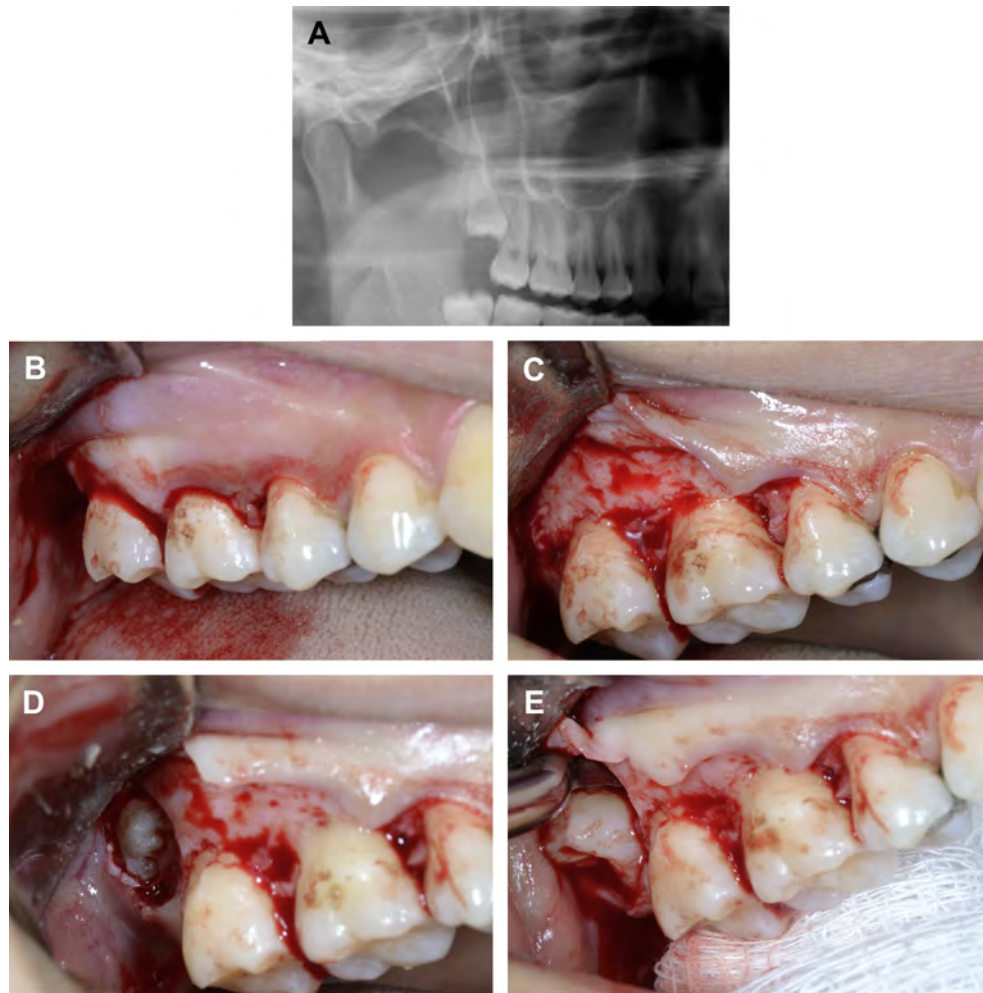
(A) Radiograph of impacted maxillary right third molar. (B) Envelope flap incision. (C) Reflection of envelope flap to access impacted maxillary third molar. (D) Bone removed overlying crown with fissure bur. (E) Impacted maxillary third molar delivered via rotation of Potts elevator.
